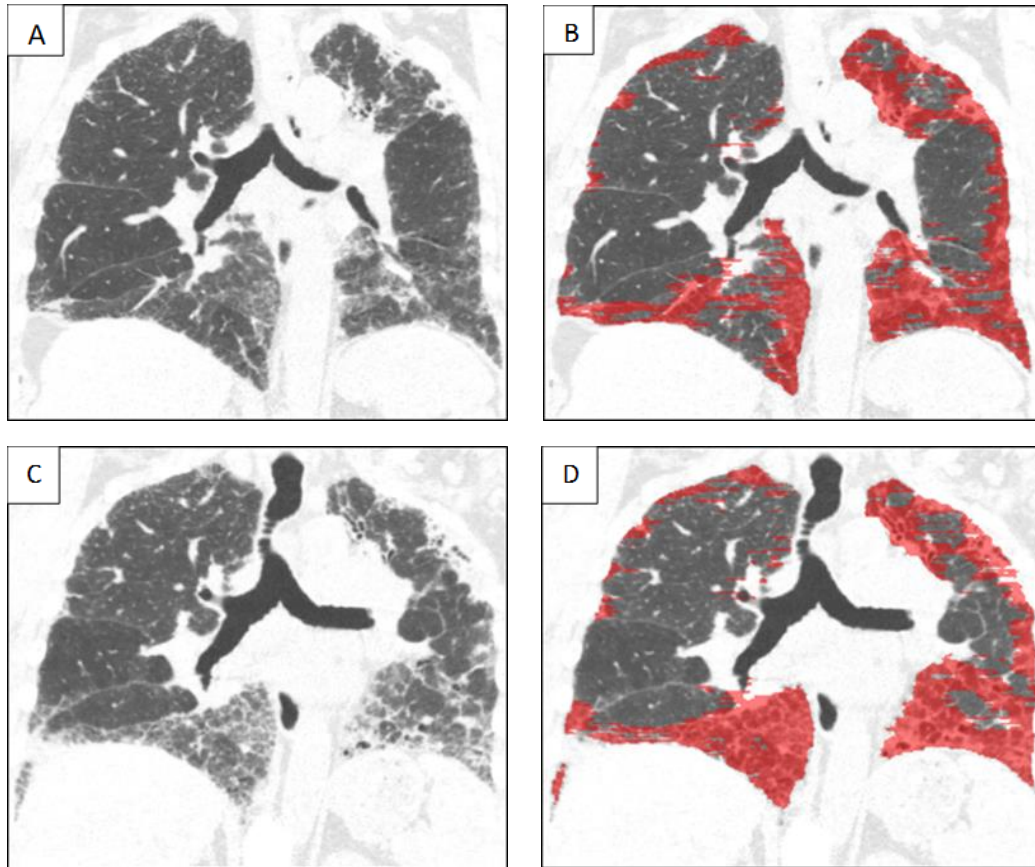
Data-driven texture analysis (DTA). Coronal CT sections on a 66-year-old female with IPF. Visual CT pattern was indeterminate for UIP. Baseline CT with B) DTA classification as red overlay. DTA score (calculated as percentage of lung volume classified as fibrosis) was 33.0 at baseline. C) Follow-up CT at 1 year and D) DTA classification as red overlay. DTA score increased to 39.0 at 1 year follow-up. Courtesy of Prof. Steve Humphries.
